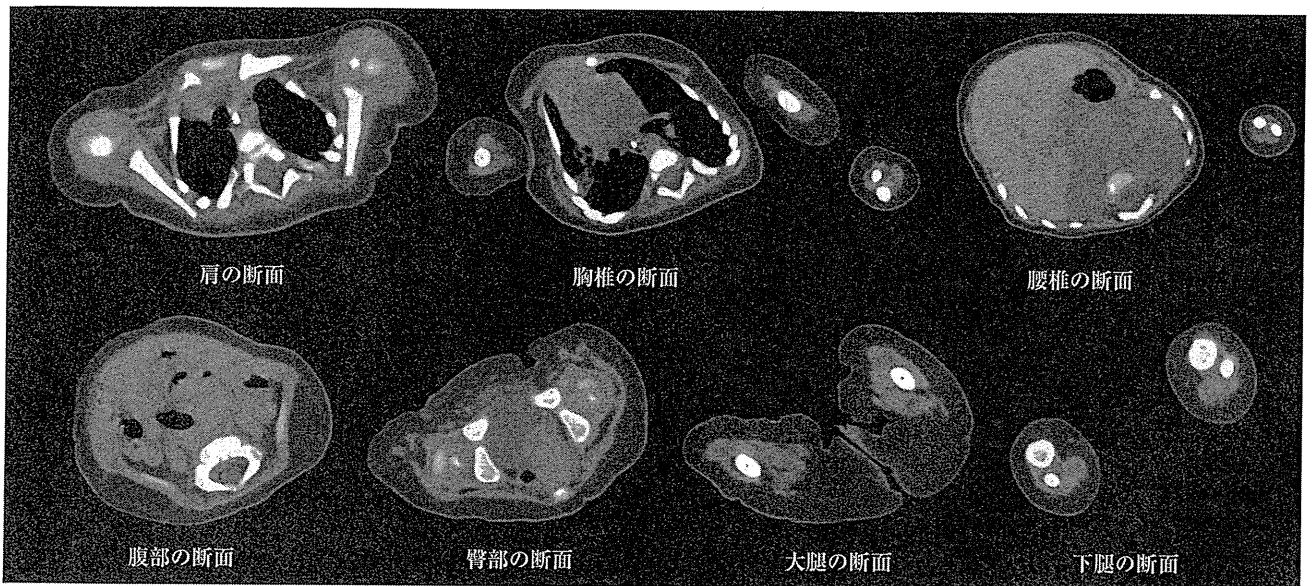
筋 CT 検査 (日齢 54, window レベル 30)
